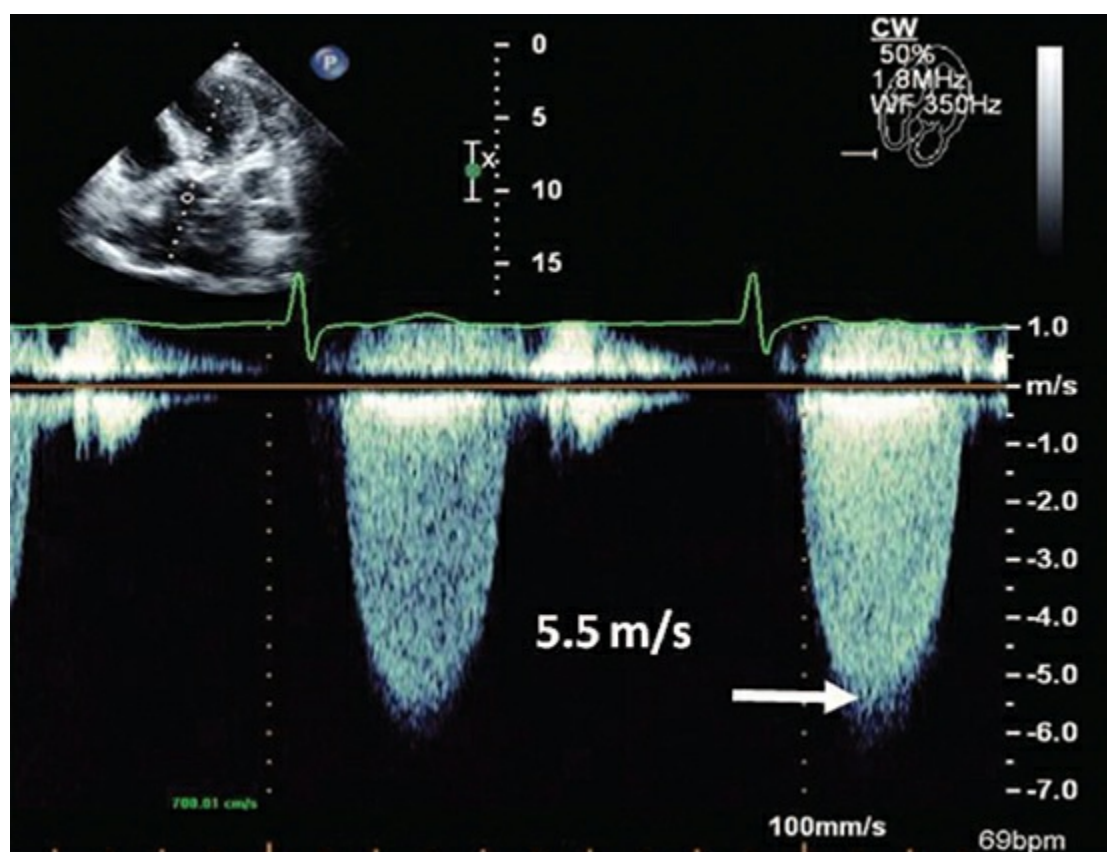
Continuous-wave Doppler tracing (from the apical transducer position) through the aortic valve in a case of severe aortic stenosis. The peak systolic velocity is 5.5 m/s, corresponding to a maximal instantaneous gradient of 121 mm Hg; the mean gradient is 80 mm Hg.
